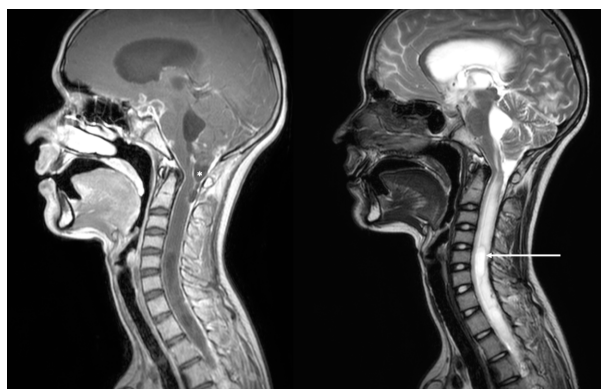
Magnetic resonance imaging (MRI) of the brain and spine demonstrates several manifestations of CNS tuberculosis. Post-contrast T1 weighted (T1w, left panel) and T2w(right panel) sagittal MRI shows diffuse leptomeningeal enhancement and thickening over the brainstem and spinal cord, exudates at the suprasellar cistern, base of the fourth ventricle, and the cervico-medullary junction leading to focal CSF loculation posterior to it (marked with an asterisk). Significant oedema and syring extending throughout the cord are evident, most prominent at C5-C6 level (white arrow).
